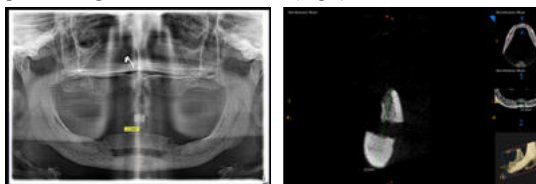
Postoperative Assessment on OPG and CBCT showing vertical bone gain after removal of distractor.
